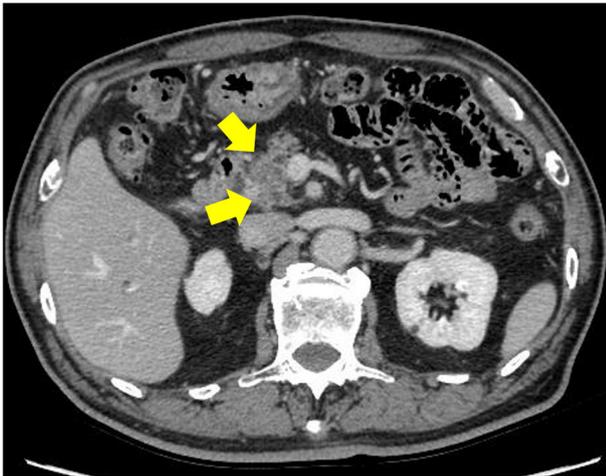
Image findings of contrast-enhanced dynamic-computed tomography before neoadjuvant chemotherapy. Image shows a hypovascular tumor of the pancreatic head (yellow arrow).
